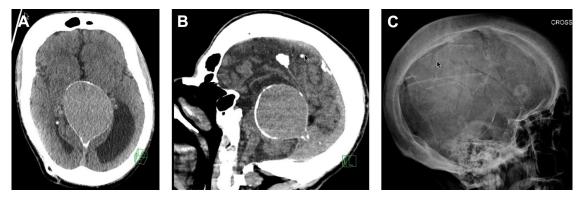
(A) A 42-year-old male with history of developmental seizures and ventricular peritoneal shunt with a giant VoGM. Noncontrast axial CT scan shows a giant midline venous dilation in the region of the quadrigeminal plate. Note the calcified rim in the wall of the venous malformation. (B) Noncontrast sagittal CT scan demonstrating a giant midline venous dilation and faint outline of its vascular communication with the straight sinus. There is also marked calvarial hyperostosis. (C) Lateral skull x-ray showing a calcified rim characteristic of a VoGM. CT, computed tomography; VoGM, vein of Galen malformation.
